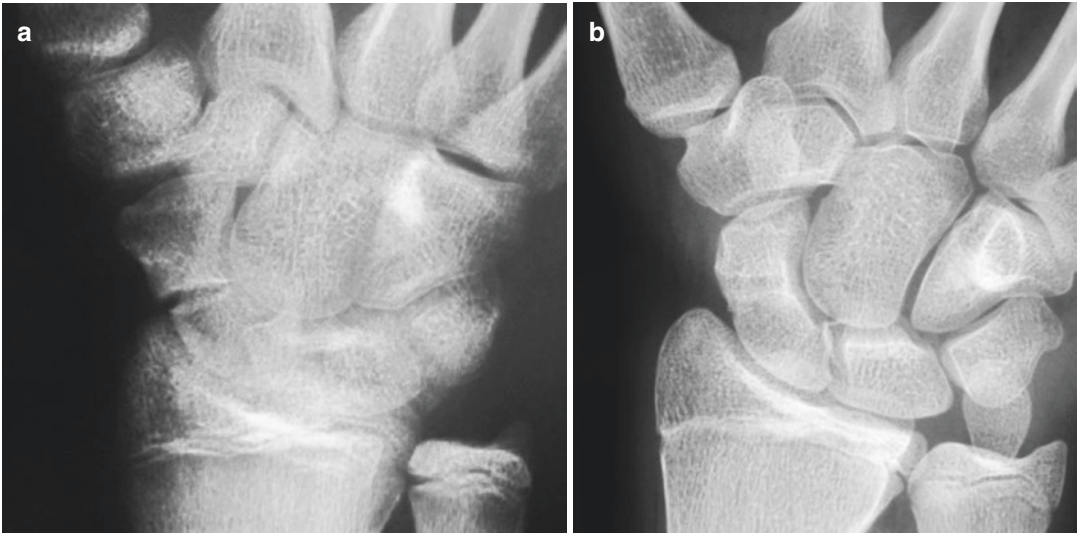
(a) A 17-year-old student, who was referred after 2 months of treatment with a plaster cast. X-ray depicts a delayed union (“nascent nonunion”). (b) X-ray
